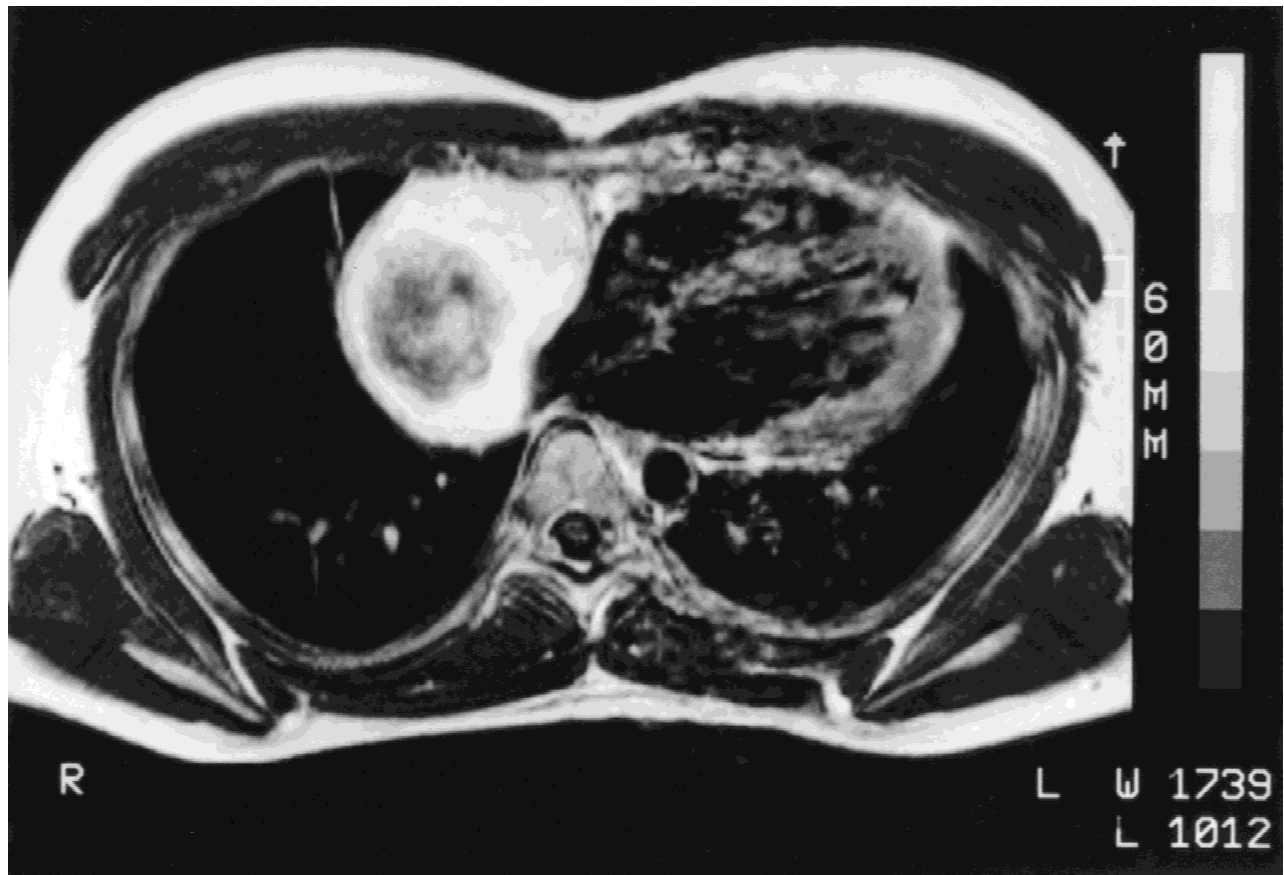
Axial postenhancement T<sub>1</sub>-weighted MRI showing an extensive mass relating to the right lateral pericardial surface (see also Fig. 2). The mass displaces the inferior part of the superior vena cava and decompresses the lateral aspect of the right atrium and runs into the inferior pericardial surface. Eccentrically within it an area of necrohaemorrhage is seen surrounded by a relatively uniformly enhancing mass of abnormal soft tissue.
